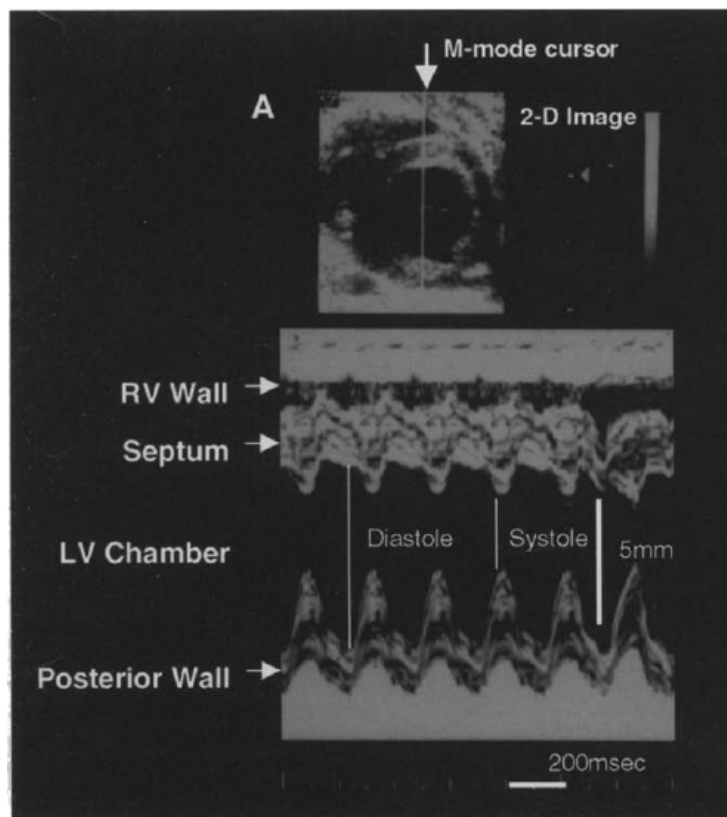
M-mode image through parasternal short axis view of the heart. Modified after⁴⁵
